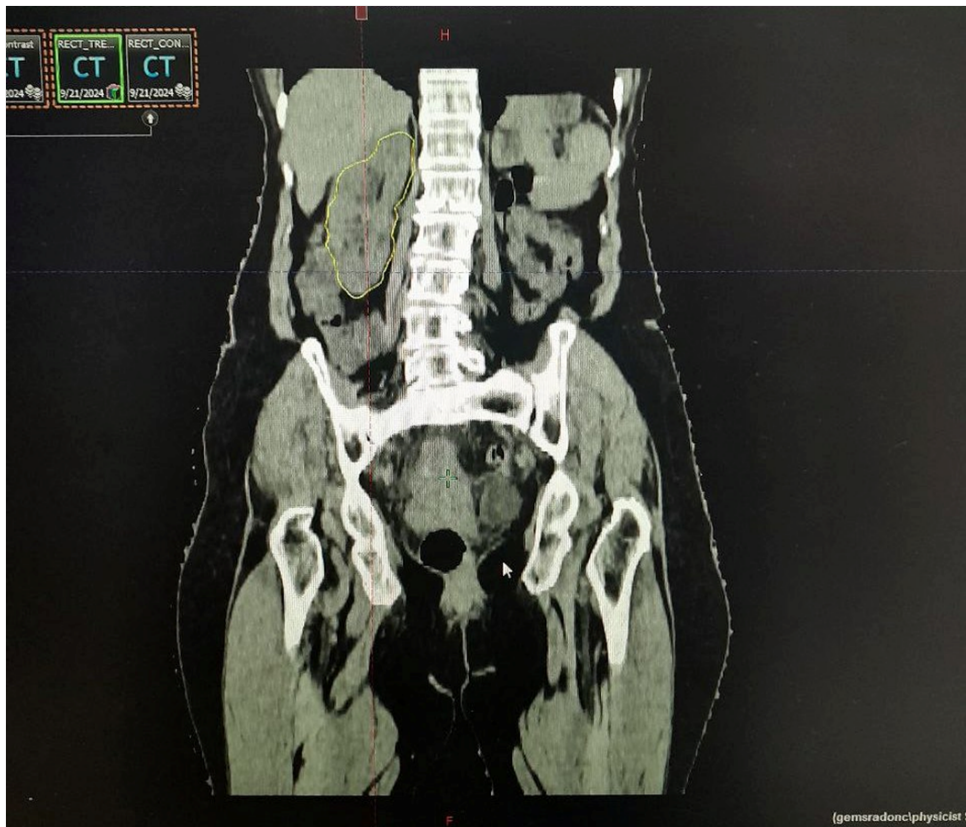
Fused kidney as seen on planning CT (Coronal section)
